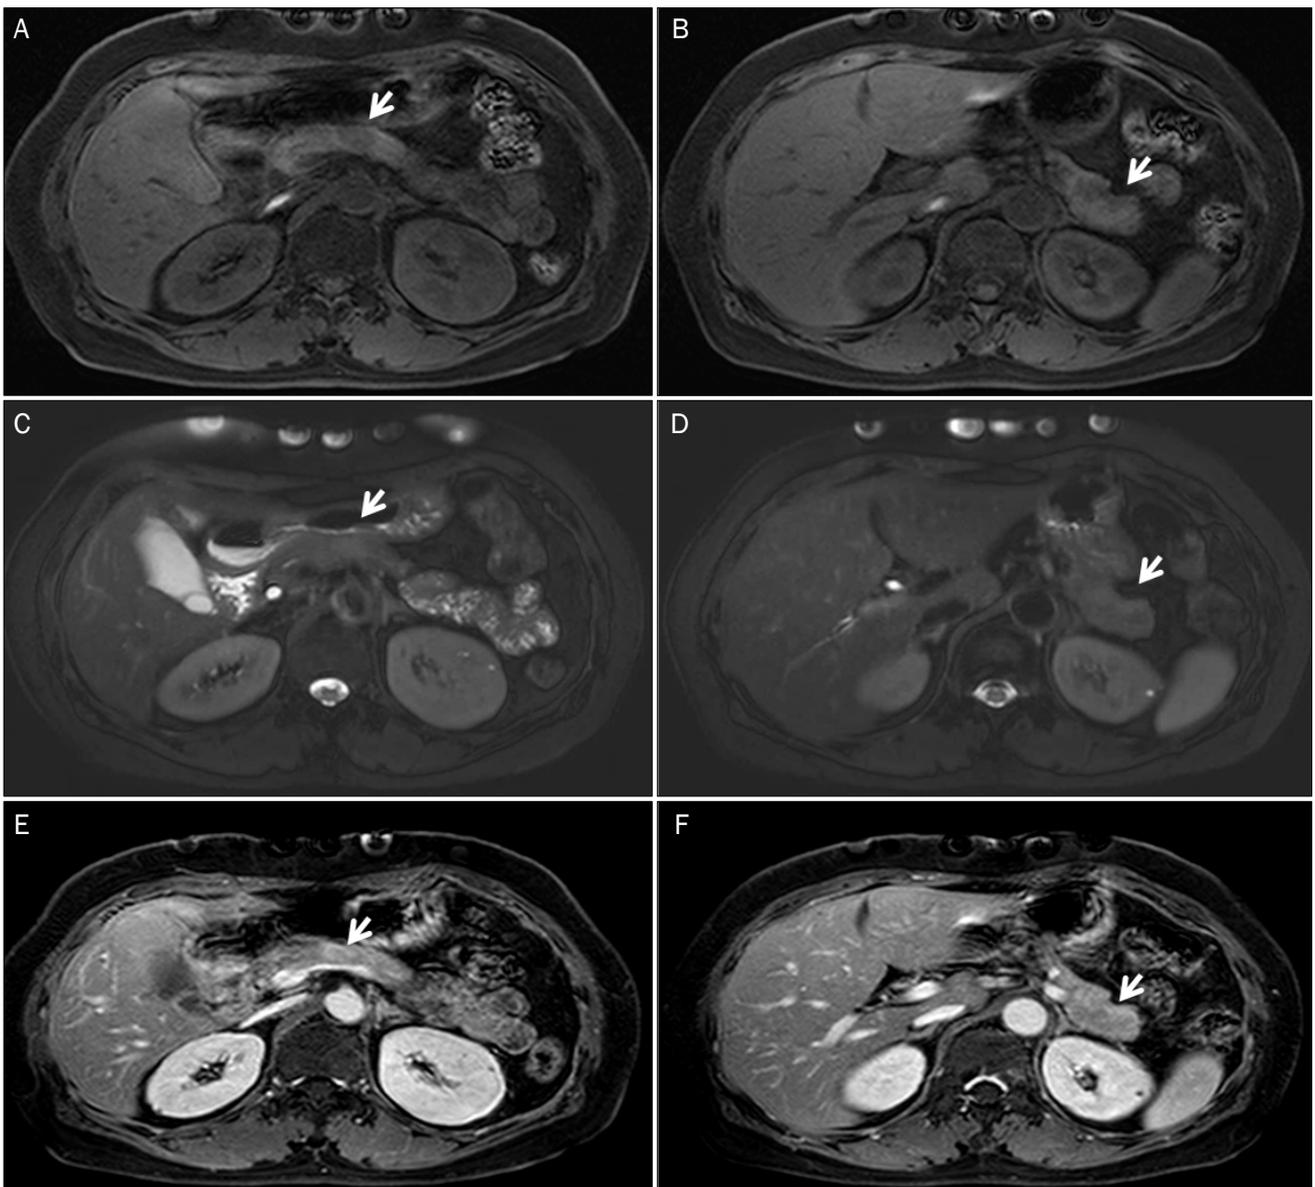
Abdominal magnetic resonance images. Pre-contrast T1 weighted axial magnetic resonance images showing hypointense masses, 1.5 cm (A, arrow) and 4.5 cm (B, arrow) sized round shapes in the body and tail of the pancreas, respectively. They show moderate high signal intensity on T2 weighted images (C, D) and homogeneous delayed enhancement in the portal venous phase after contrast enhancement (E, F), suggesting solid tumors (arrows).
